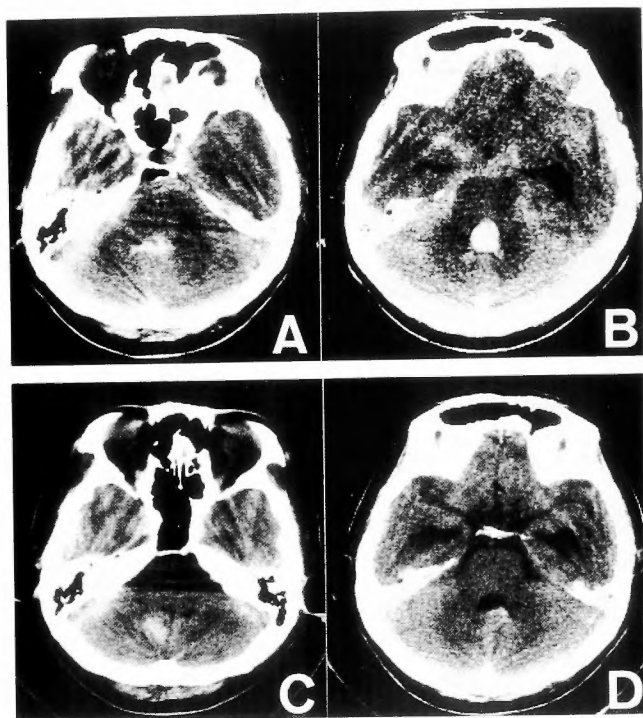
CT scans on day 0 (A,B) show ventricular hemorrhage, especially marked in the fourth ventricle, and subarachnoid hemorrhage. Repeat CT scans on day 14 (C,D) show a small hematoma in the right lower cerebellum near the midline.
